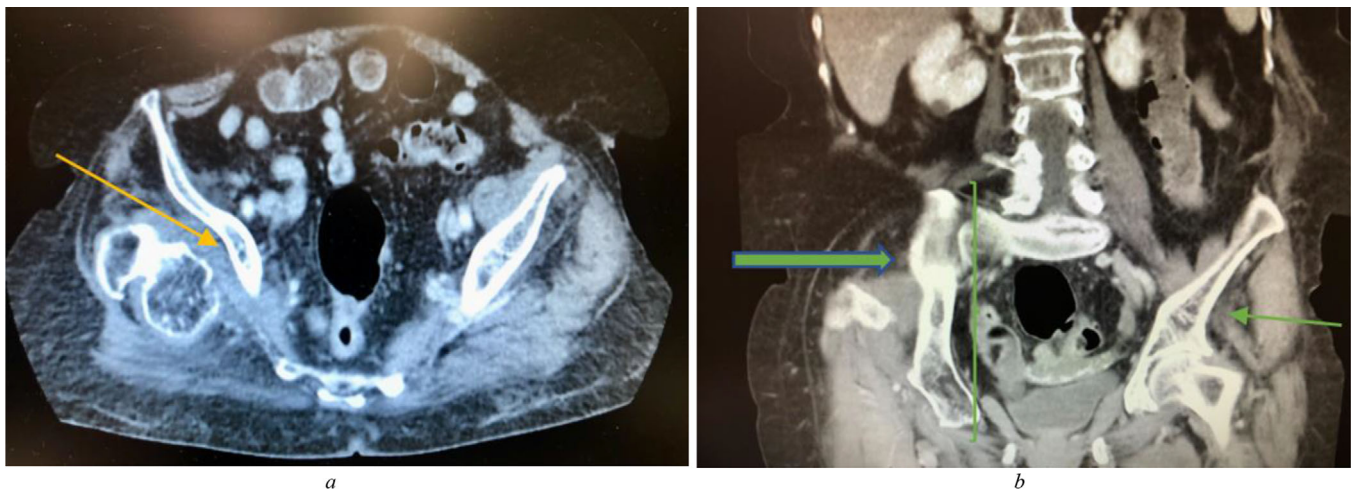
(A) Pseudo-acetabulum formation adjacent to the right femoral head on the ilium (arrow). The right femoral head demonstrates arthritic like changes. The left femoral head (not pictured) intact without changes. (B) Computed tomography imaging of the right ilium that is medially rotated and displaced (thick arrow) compared to the left ilium (thin arrow) likely as a result of compensatory adaptations
